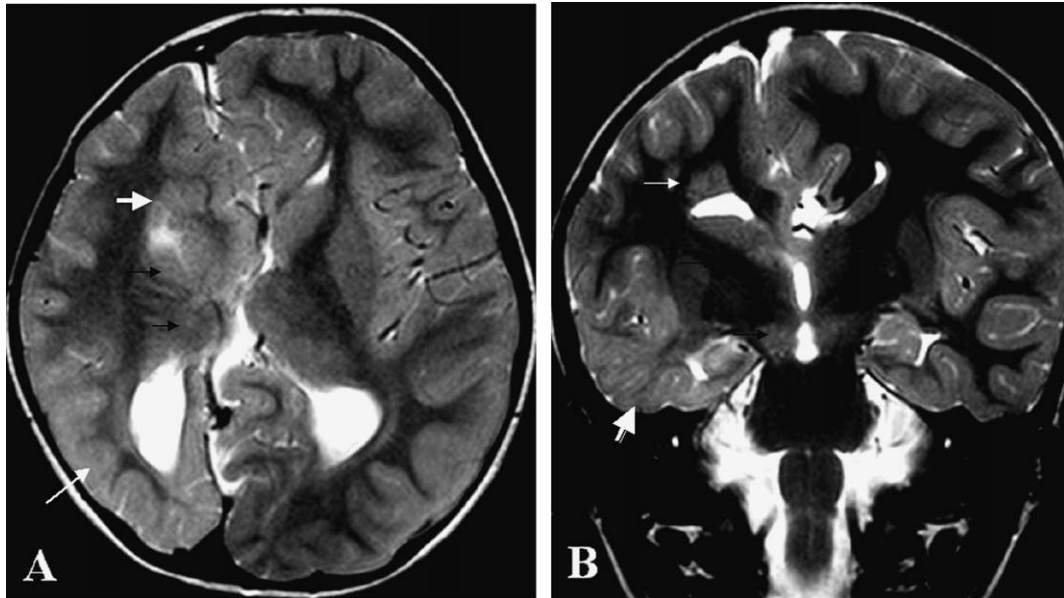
T2-weighted axial (A) and coronal (B) magnetic resonance images of the brain of case 1. Subcortical heterotopia in the right frontoparietal white matter with overlying thin cortex (thin white arrow) and dysplastic basal ganglia and thalamus (black arrows) is evident. The right hemisphere appears small. Note the absence of corpus callosum and poorly formed sylvian fissure. Gray–white differentiation in the right temporal lobe is poor (arrowhead). Left hemisphere appears larger and crosses the midline. However, the gray–white differentiation is normal, with no evidence of increased signals in the white matter.
